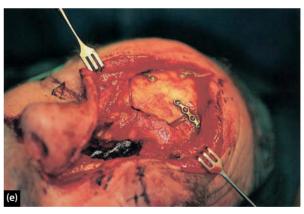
Stages of an anterior craniofacial resection. (a) pre-operative CT acquired face down; (b-e) resection; (f) post-operative CT.
